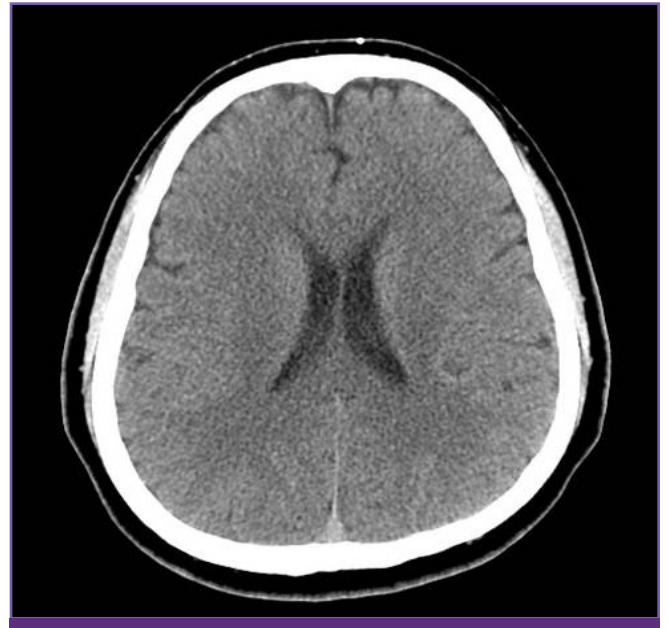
7-month follow-up brain CT shows a subtle residual low-density lesion in the left frontal lobe cortex and subcortical white matter junction. The size of the abscess and the extent of the perilesional edema are reduced.
